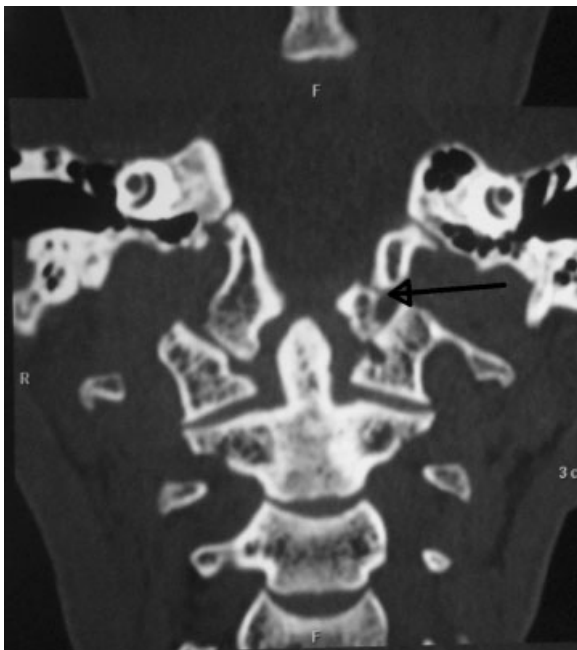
CT craniocervical junction: Fracture of left basioccipital and two left occipital condyle.
